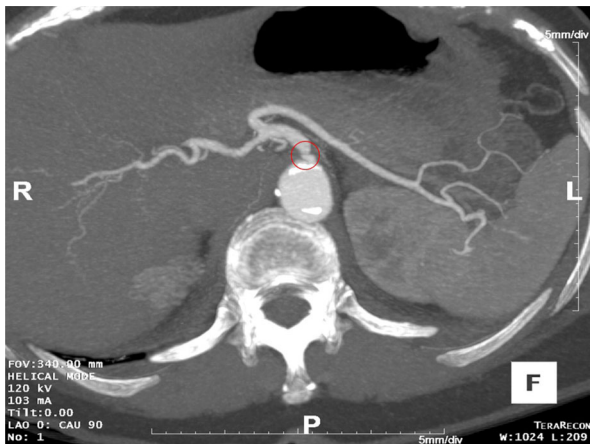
Computed tomographic angiography (CTA) of the abdomen revealing luminal stenosis of the proximal 1 cm of the celiac axis estimating 90% occlusion, typical for median arcuate ligament syndrome, and a patent SMA and IMA.
